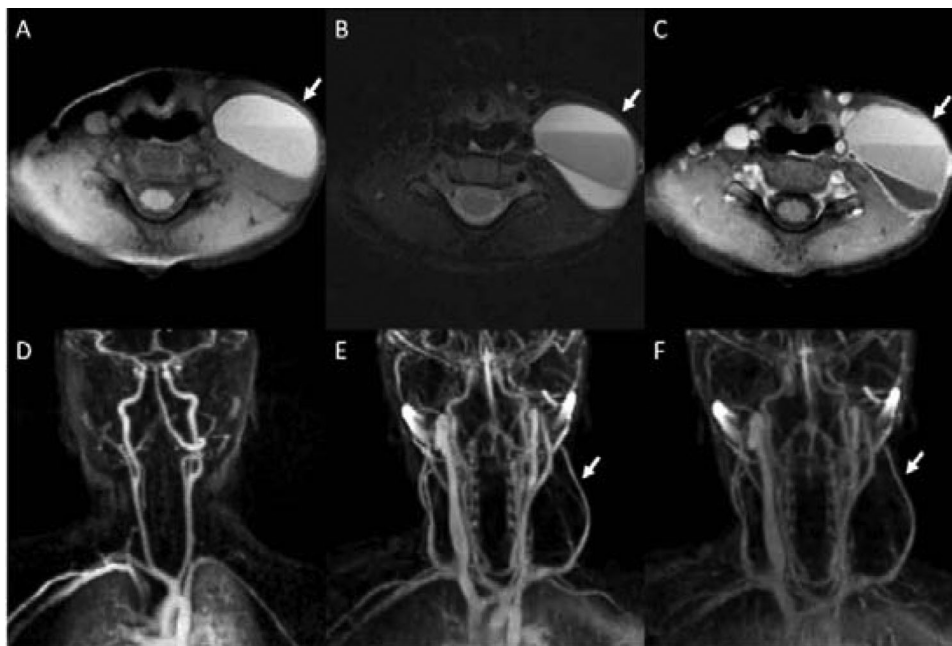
Axial fat-suppressed T1-weighted (A), fat-suppressed T2-weighted (B), and contrast enhanced fat-suppressed T1-weighted (C) MR images of a child with a lymphatic malformation. The axial images show a large, well-defined macrocystic cystic structure in the left posterior cervical triangle. The cyst demonstrates fluid-fluid levels and enhancement of the peripheral cyst wall and septa (C). Multiphasic dynamic contrast-enhanced MRA images (D-F) reveal no arterial or venous enhancement of the lesion. Note the displacement of the external jugular vein due to mass effect (E, F).
